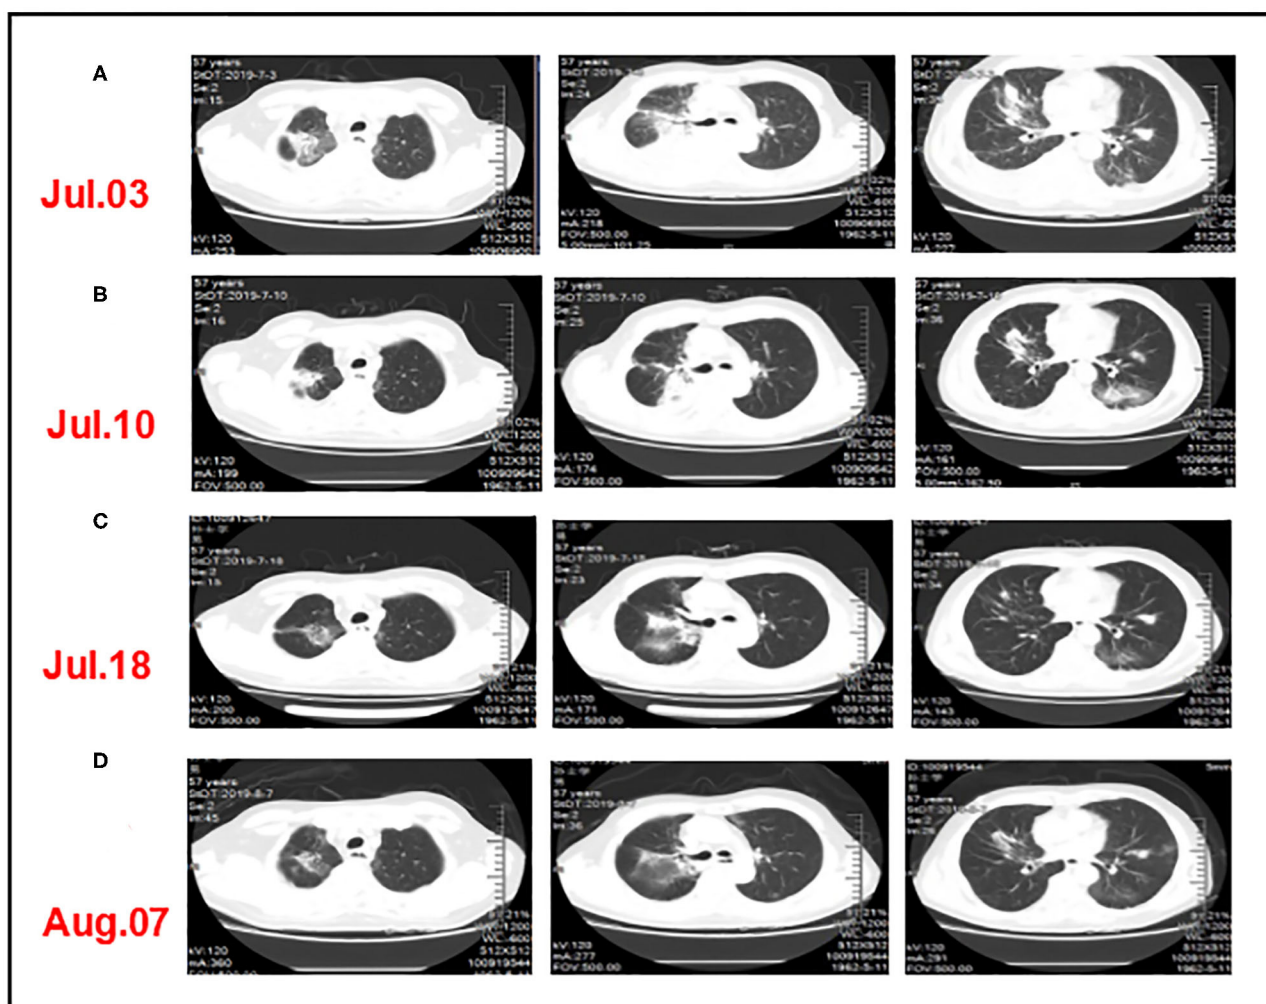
CT comparison of the patient's lung inflammation during anti-infective treatment. (A) After three cycles of triple-combination therapy and two cycles of sintilimab monotherapy, chest computed tomography showed inflammatory changes in the lungs and partial lung consolidation. (B,C) The chest CT showed that pulmonary infiltration was absorbed after taking a sufficient amount of steroids and antibiotics. (D) The patient had a "flare" of pneumonitis symptoms when quickly tapered off steroids.
